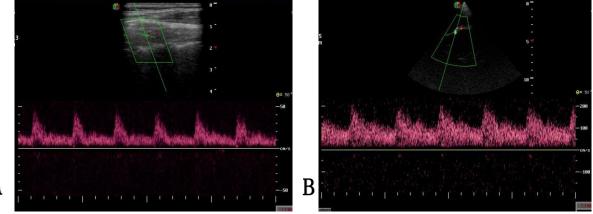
The position of the trans-temporal window demonstrates the Doppler effect of the MCA. A. The orientation of the probe index mark is directed towards the patient's anterior/front. B. A typical spectral Doppler velocity waveform from the MCA showed a sharp peak systolic velocity (PSV) and a gradual decrease in end-diastolic velocity, with a mean flow velocity (MFV) of 64.3 cm/s.
